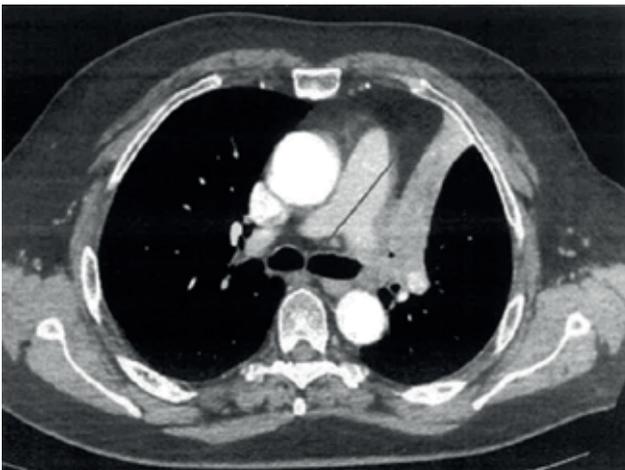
Preoperative axial chest CT scan showing the line of pulmonary artery resection performed (green line), leaving sufficient caliber for the right pulmonary artery.
